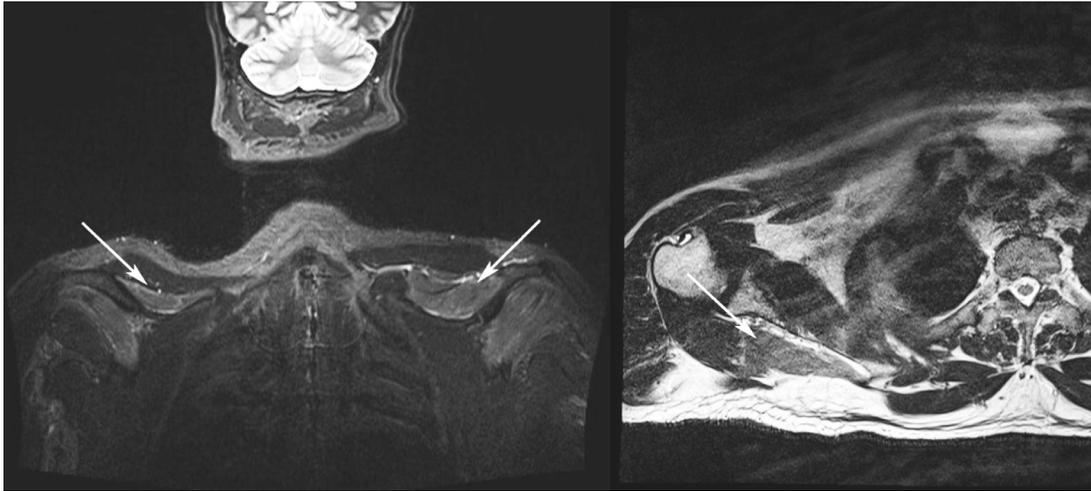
MRI images of a patient with bilateral neuralgic amyotrophy. T2 scan demonstrating increased signal intensity of supraspinatus muscles as a result of denervation. Left showing denervation of bilateral supraspinatus muscles in coronal plane, and right showing denervation of right supraspinatus muscle in transverse plane. The arrows indicate denervated supraspinatus muscles.
